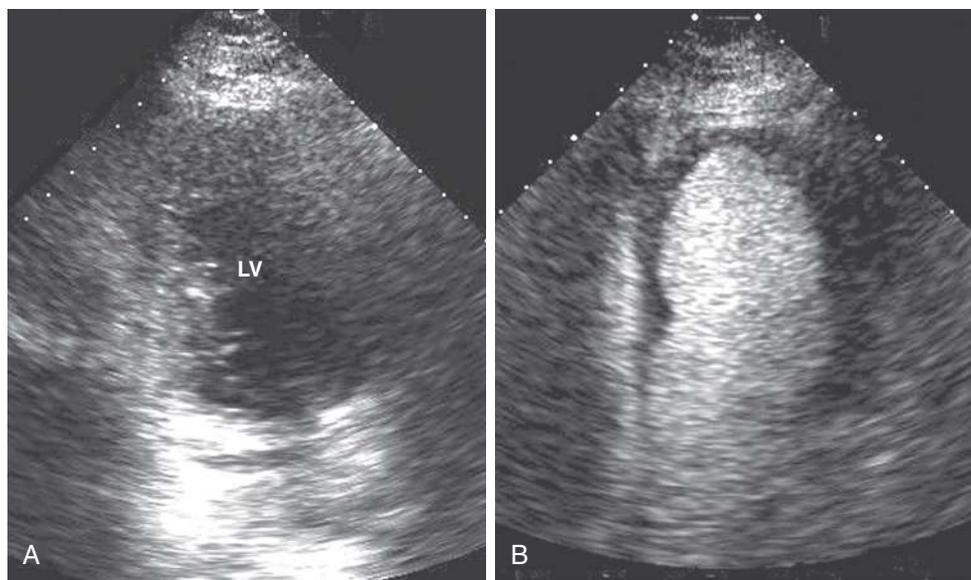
Use of contrast agent to improve endocardial border delineation in a critically ill patient with suboptimal transthoracic image quality. A suboptimal transthoracic apical two-chamber view (A) of the left ventricle (LV) obtained from a ventilated ICU patient with hemodynamic instability. The poor endocardial resolution makes regional and global ventricular function hard to assess. Same transthoracic two-chamber apical view (B) in the same patient after contrast injection. A dramatic improvement in endocardial border definition is noted. Contrast echocardiography combined with harmonic imaging provides a noninvasive, safe alternative to transesophageal echocardiography for determination of regional and global left ventricular function.
